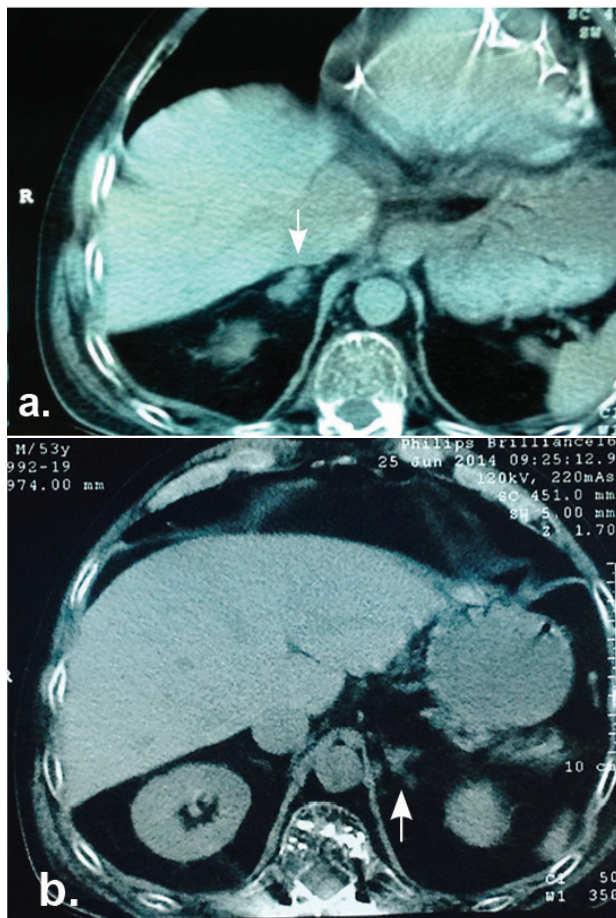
Adrenal computed tomography revealing bilateral nodularity of the adrenal glands.
